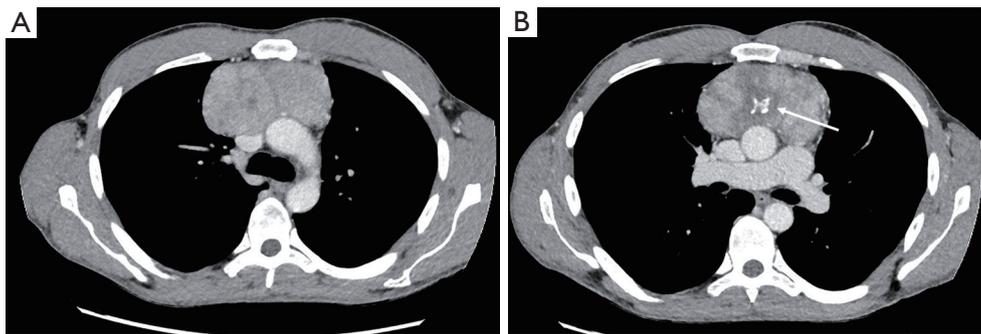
Axial contrast-enhanced chest CT images showing a large mass in the prevascular mediastinal compartment. (A) The tumour is lobulated and well-defined, and (B) has a heterogeneous aspect, with low-density areas corresponding with necrosis as well as an area of chunky calcifications (white arrow). CT, computed tomography.
